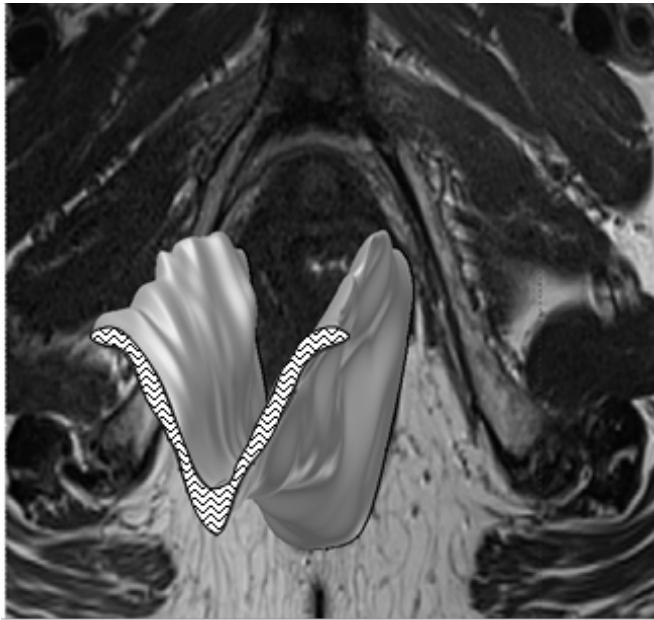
Construction of 3D model based on MR image.
